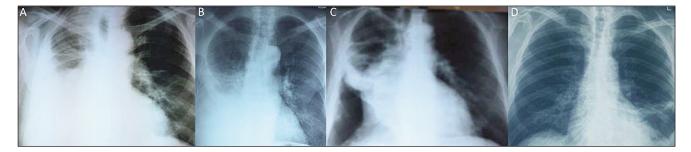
PA chest X-rays show at admission showing a massive pleural effusion, enlarged cardiac silhouette and inflammatory changes in upper parts of right lung (A); reduction of pleural effusion (C); round SHARP shadows in incisura (C); complete radiological resolution after six days of treatment for congestive heart failure (D)
